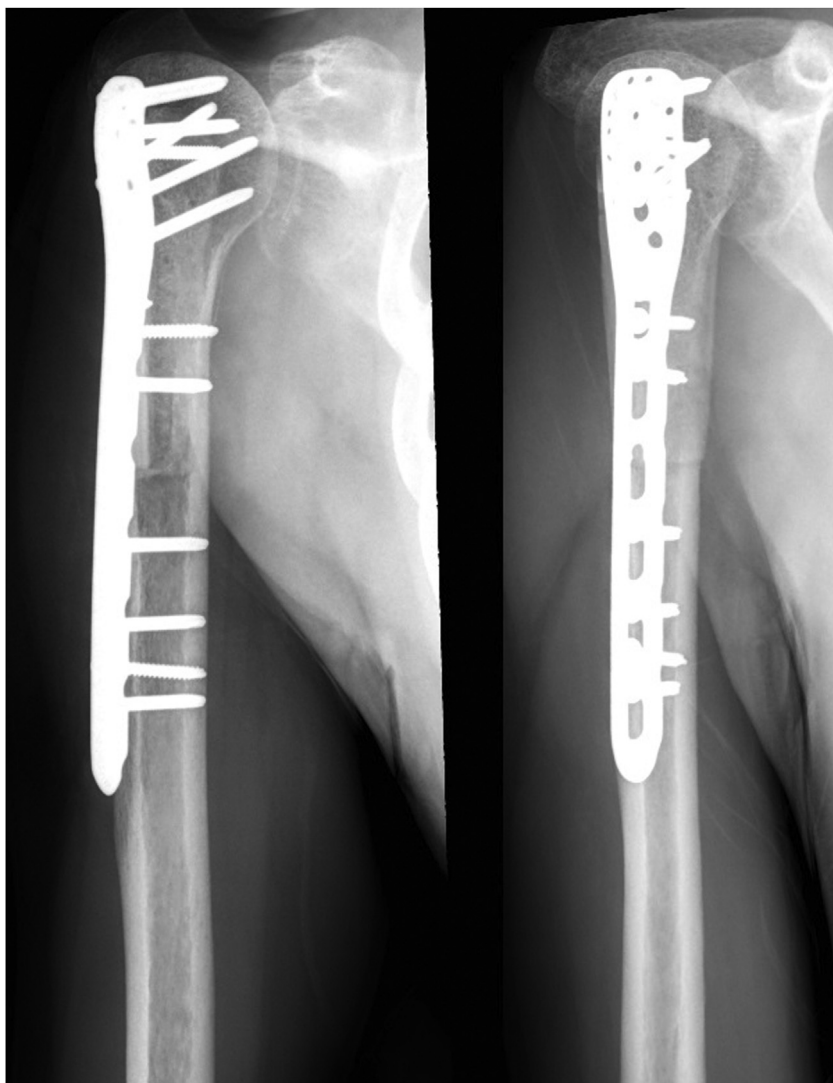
Postoperative AP and lateral radiographs of the proximal humerus. The hemicortical allograft is demonstrated proximally with spanning plate fixation. The osteotomy site is still identified.
